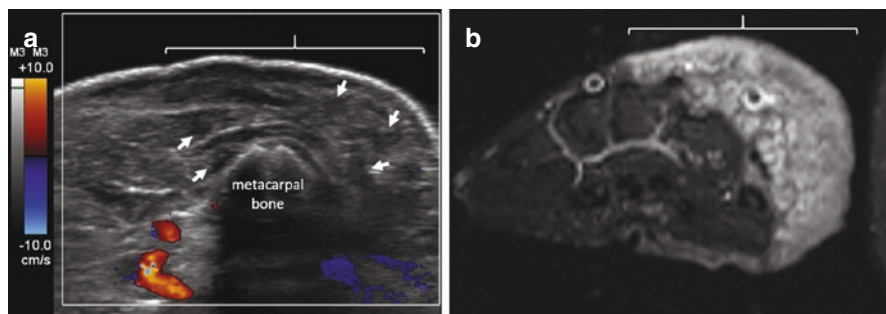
Transverse ultrasound of the right wrist in a 12-year-old male (a) with neurofibromatosis type 1 shows a diffuse heterogeneous area in the subcutaneous tissues (white bracket) containing multiple small hypoechoic lesions (examples shown with small white arrows). These features represent plexiform neurofibroma, also demonstrated by T2-hyperintense signal on magnetic resonance (MR) imaging (b). Although MR has superior contrast (black/white) resolution, ultrasound has better spatial resolution to evaluate small details
